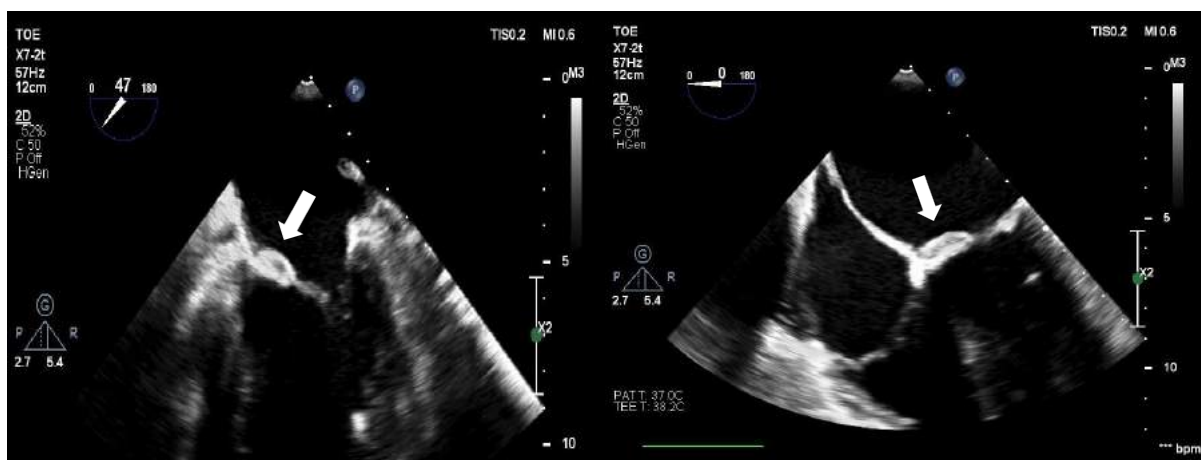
Trans esophageal echocardiogram [TOE] images showing subsequent enlargement of anterior mitral valve leaflet abscess left image at 2 weeks and right image at 6 weeks.
